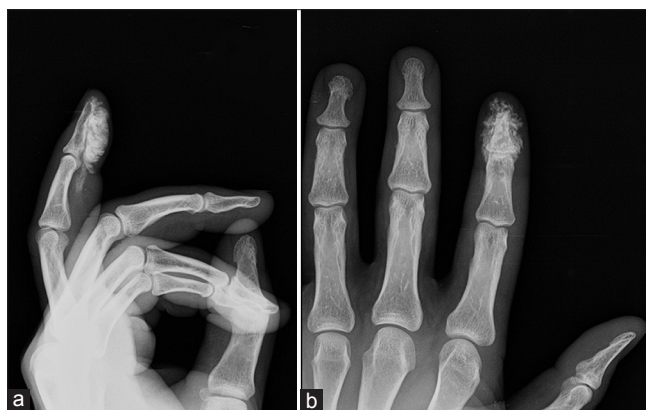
(a) Lateral radiographic view; (b) anteroposterior radiographic view of the patient, the radiopaque appearance of the paint could be recognized clearly
